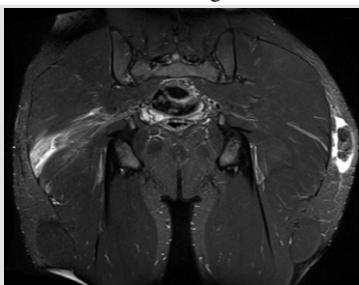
T2-weighted coronal magnetic resonance imaging slice showing the fat fracture with surrounding edema in the adipose tissue between the subcutaneous tissue and fascia of the left thigh.
